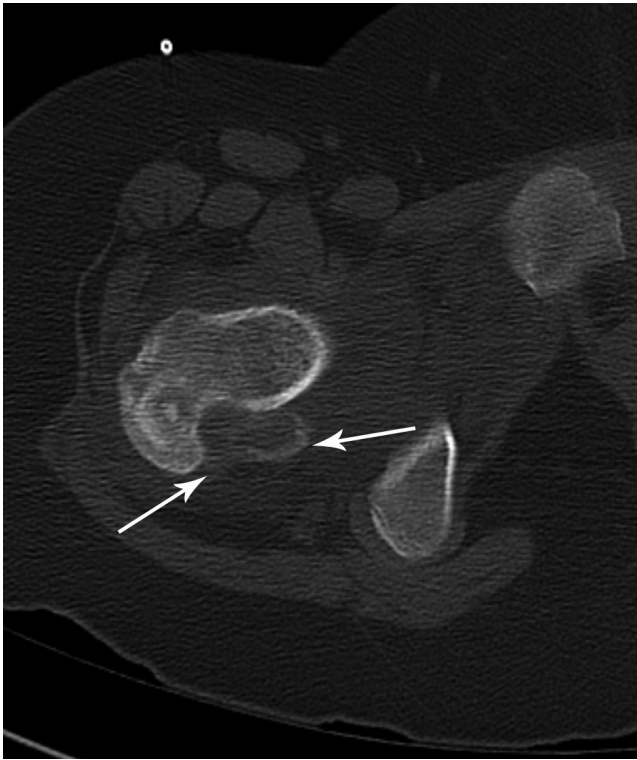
10-year-old girl with recurrence of chondroblastoma. CT of the right hip obtained in conjunction with biopsy, depicted on the bone window. Soft-tissue mass posteromedial to the greater trochanter surrounded by a thin interrupted rim of calcification (arrows).
